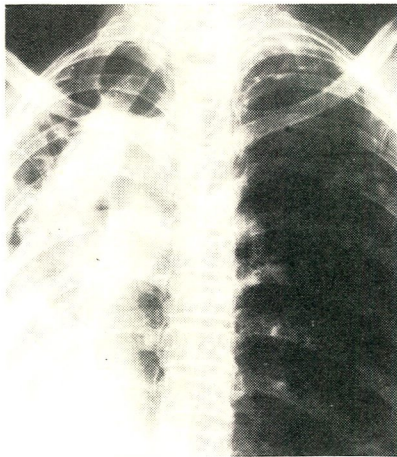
Case No. 1. Pre-operative Chest X-ray showing marked Mediastinal shift to the left, contracted left Lung, Cystic changes in the left Apex and residual Ribrotic changes in the right Apex.
